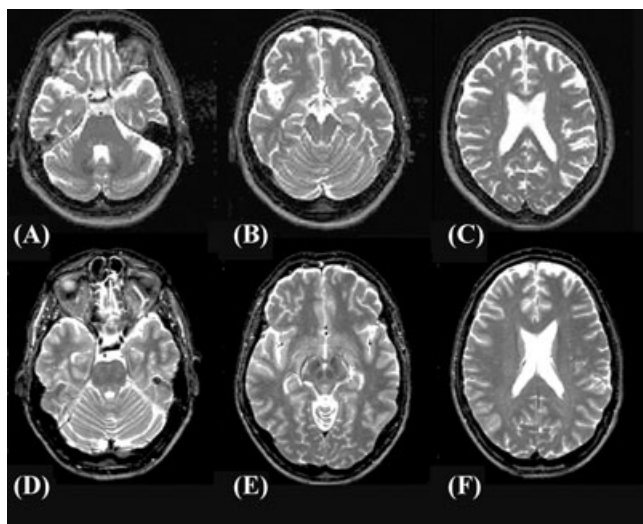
T2-weighted magnetic resonance images of a patient in the early stages of FTD (A-C) showing relatively selective OFC atrophy and a healthy age-matched control subject (D-F) for comparison.
